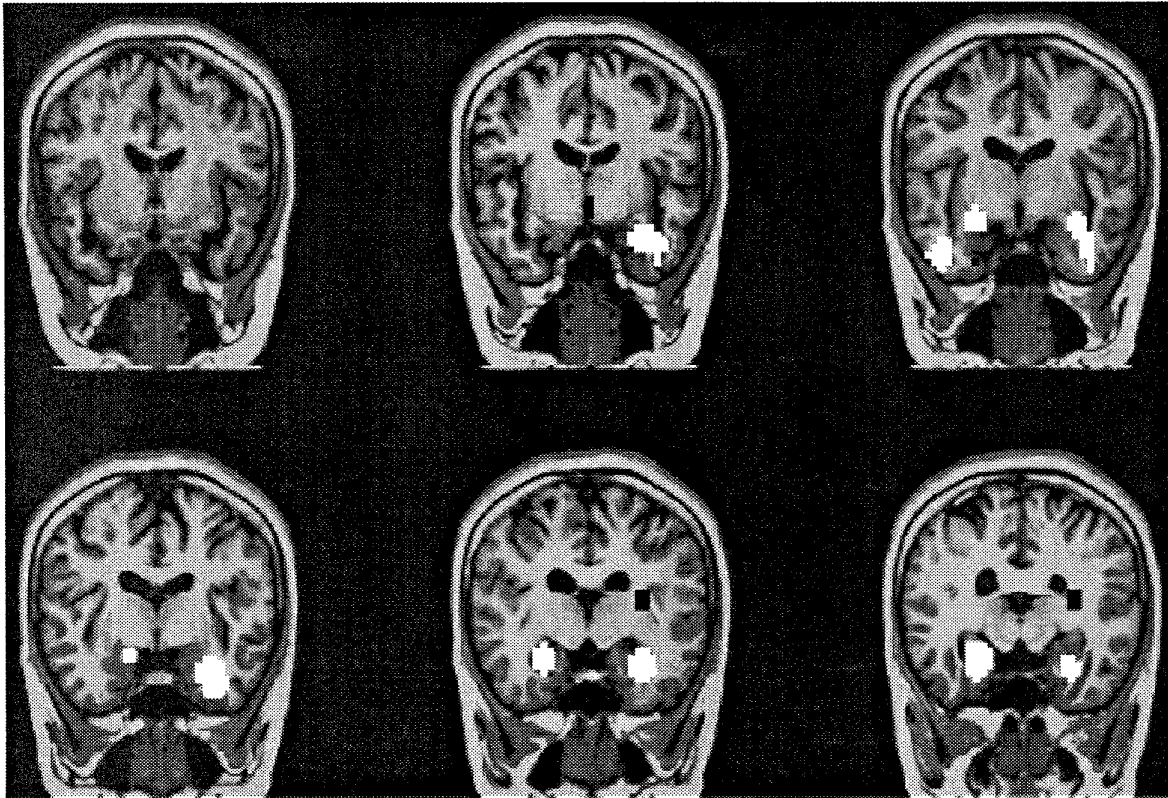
Contiguous coronal MRI slices (anteroposterior direction from top left to bottom right), tilted at an angle of  $45^\circ$  from postero-superior to antero-inferior. Superimposed are significant functional signal differences  $>1\%$  due to olfactory stimulation (positive - white, negative - black).
